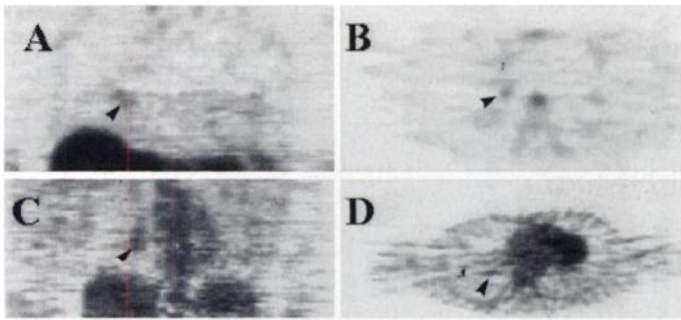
Low-grade uptake of MET (A and B) and FDG (C and D) (indicated by the arrowheads) in the lung fields of patients with Kaposi's sarcoma.
